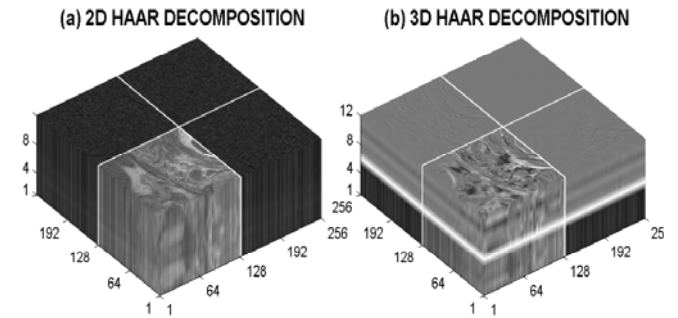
Decomposition of the set of MR images presenting (a) 2-D slice-by-slice Haar wavelet decomposition (b) 3-D volumetric Haar wavelet decomposition
